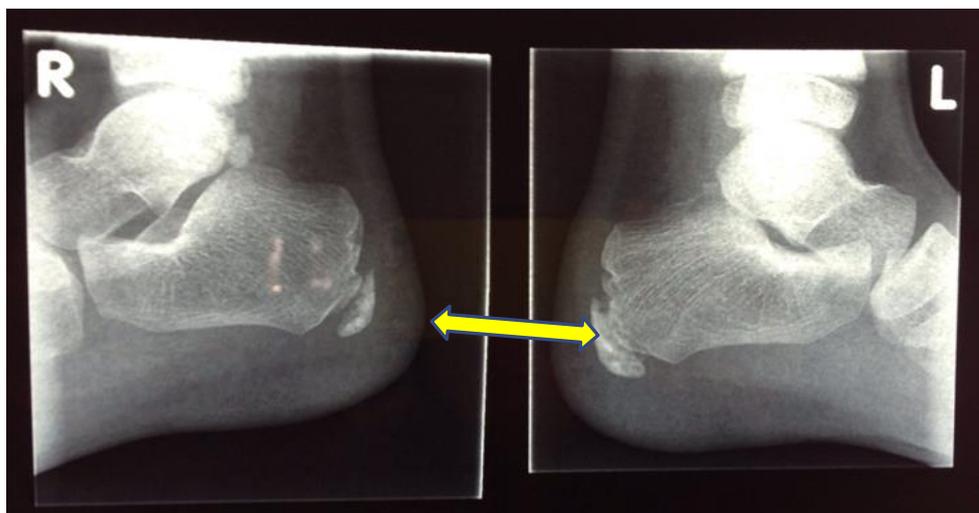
X-ray of bilateral Sever's disease showing detached bony fragments (arrows) in a 12-year-old boy (Author's photo)
